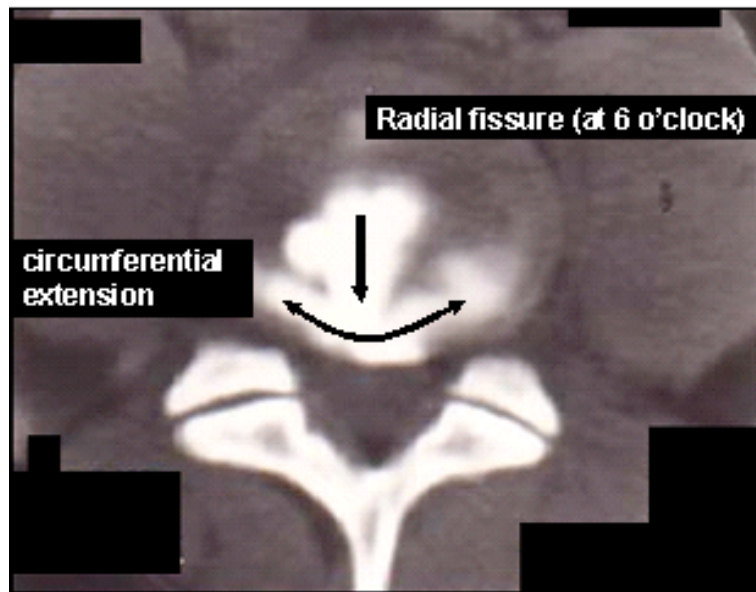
The diagnostic features of internal disc disruption on CT-discography.
